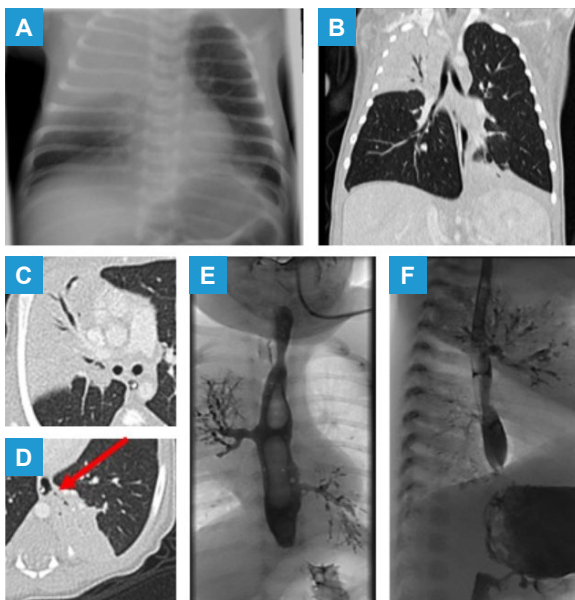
Chest X-ray (A) showing consolidations in the upper two thirds of the right lung and behind the heart on the left side. Computed tomography (B and C) suggests atresia of the right upper and middle lobe bronchus, probably arising from a common bud. However, on the left side, all bronchi except for the superior and the posterior-basal left lower lobe bronchi are patent. The course of the latter is suspicious of an esophageal bronchus (D, arrow). The upper gastrointestinal series shows esophageal insertion of a common right upper and middle lobe bronchus, as well as a common bronchus of segments VI and X on the left side (E and F).
